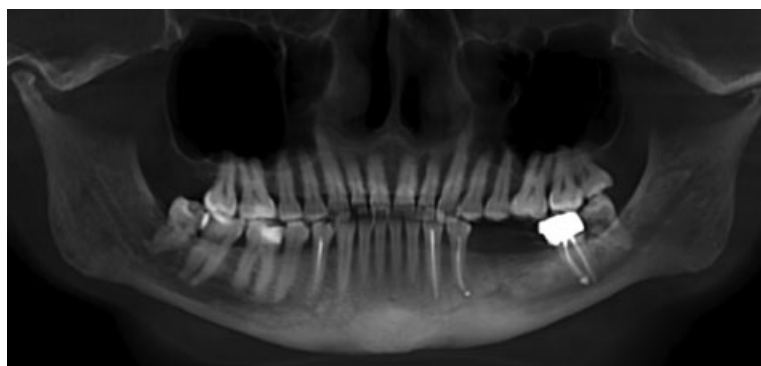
A panoramic radiograph, following endodontic treatment of teeth 34 and 37.
